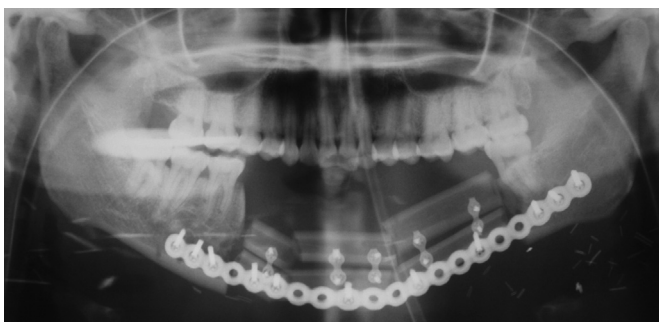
Panoramic X-ray after mandible reconstruction with double barrel free flap.
